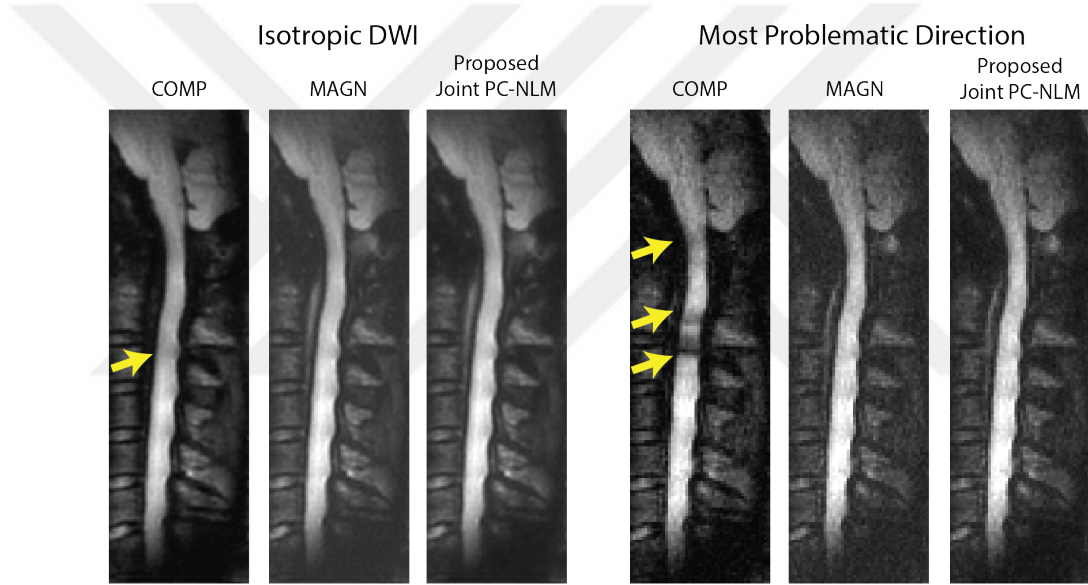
Isotropic DWI images and the DWI images from the most problematic direction (i.e., A/P direction). The isotropic DWI images show reduced sensitivity against noise and signal cancellations, as all diffusion directions are utilized to form these images. On the other hand, yellow arrows in the most problematic direction ($[G_{SI}, G_{AP}, G_{RL}] = [0 \ 1 \ 0]$), depict the severe local signal cancellations in COMP. In MAGN, see the noise accumulation at the background. The proposed joint PC-NLM yields an image without any noise accumulation and local signal cancellations.
